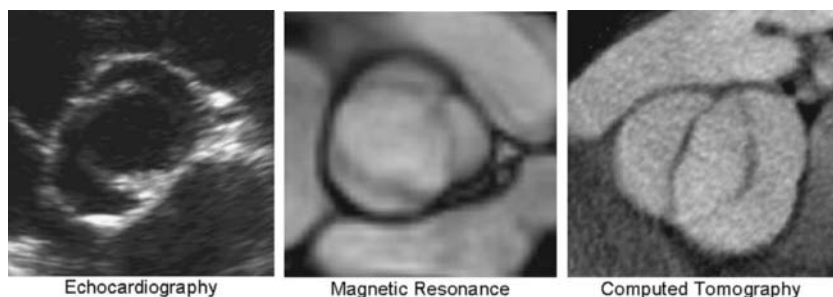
BAVs as viewed using various imaging modalities. Echocardiography is the standard. MRI and CT offer some additional resolution of imaging the ascending and descending aorta when needed, but are otherwise not necessary if acoustic windows are adequate. As with echocardiography, MRI can also measure velocity and flow through a stenotic valve, but CT cannot. CT also requires contrast and radiation.
